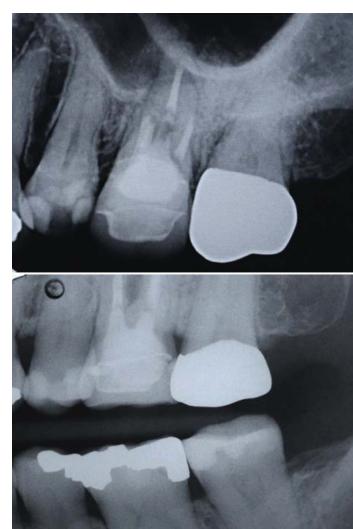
The radiographs showed proper adaptation with the restoration margin was placed approximately 2 mm above the alveolar bone level.
